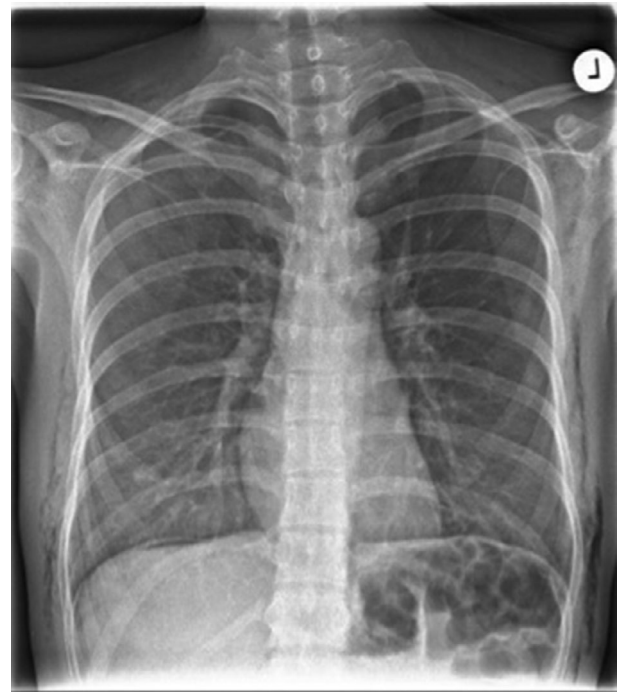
Repeat chest X-ray 24 hours postoperatively, showing (a) air under the right hemidiaphragm and (b) partial resolution of right pneumothorax
